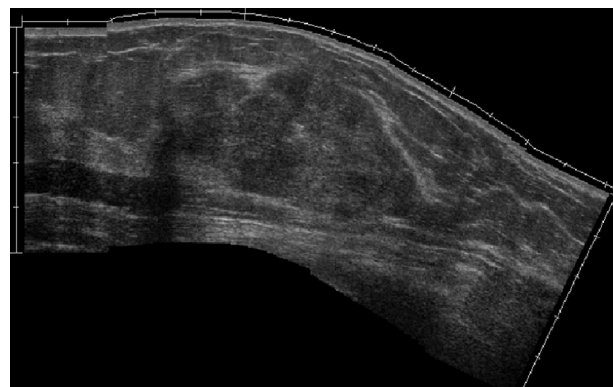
Ultrasound examination of the left breast revealed a well-defined, lobulated, and hypoechoic mass measuring 6 cm × 4 cm.
